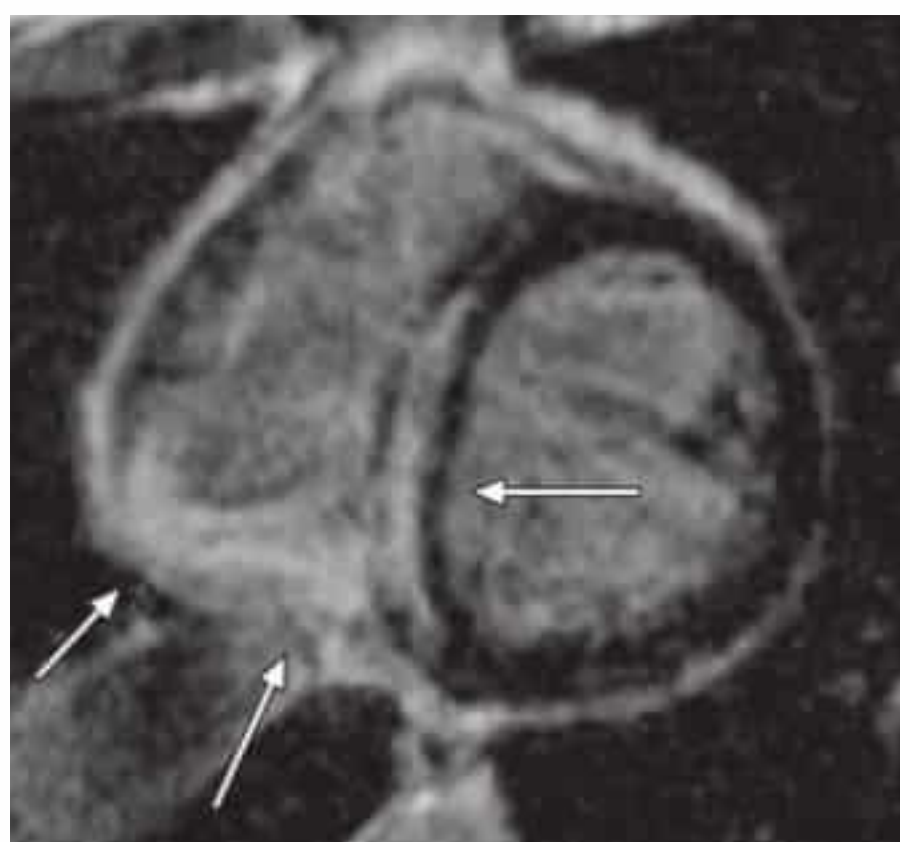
Known sarcoidosis associated with varying AV conduction abnormalities in a 35-year-old woman. MRI detected cardiac involvement with extensive inflammatory infiltrates in the right ventricle and interventricular septum (arrows).
